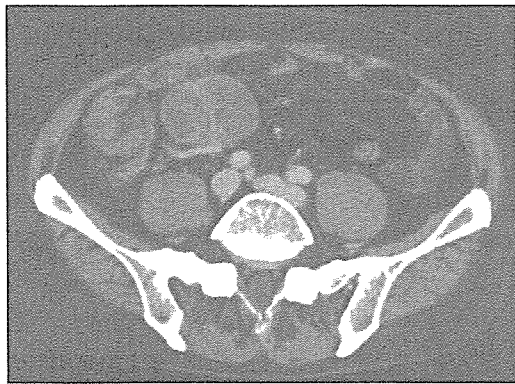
Abdominal computed tomography showing a bulky mass approximately 50 mm in diameter, suggestive of nodal involvement around the primary cecal cancer.
